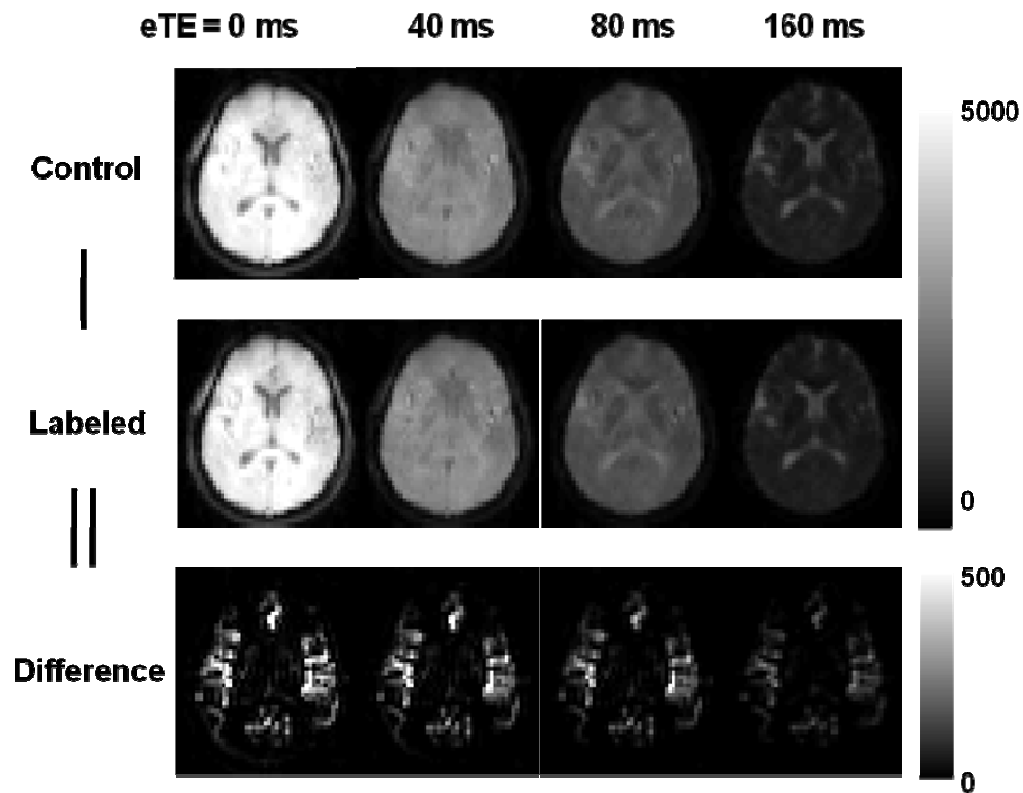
TRUST MRI images for the arterial side.
